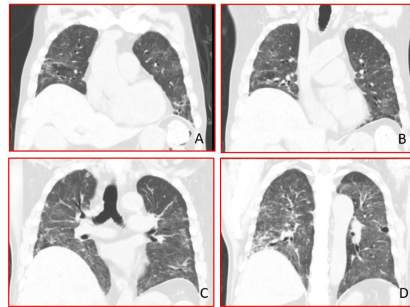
Show CT abnormalities of lung parenchyma after 14th day SMX-TMP treatment. (A)-(C) show progressive reticulation with nodularity in both lungs; (D) shows extensive GGO and reticular opacity. Cystic changed and traction bronchiectasis were also noted. Abbreviation. SMX-TMP: Sulfamethoxazole-Trimethoprim
